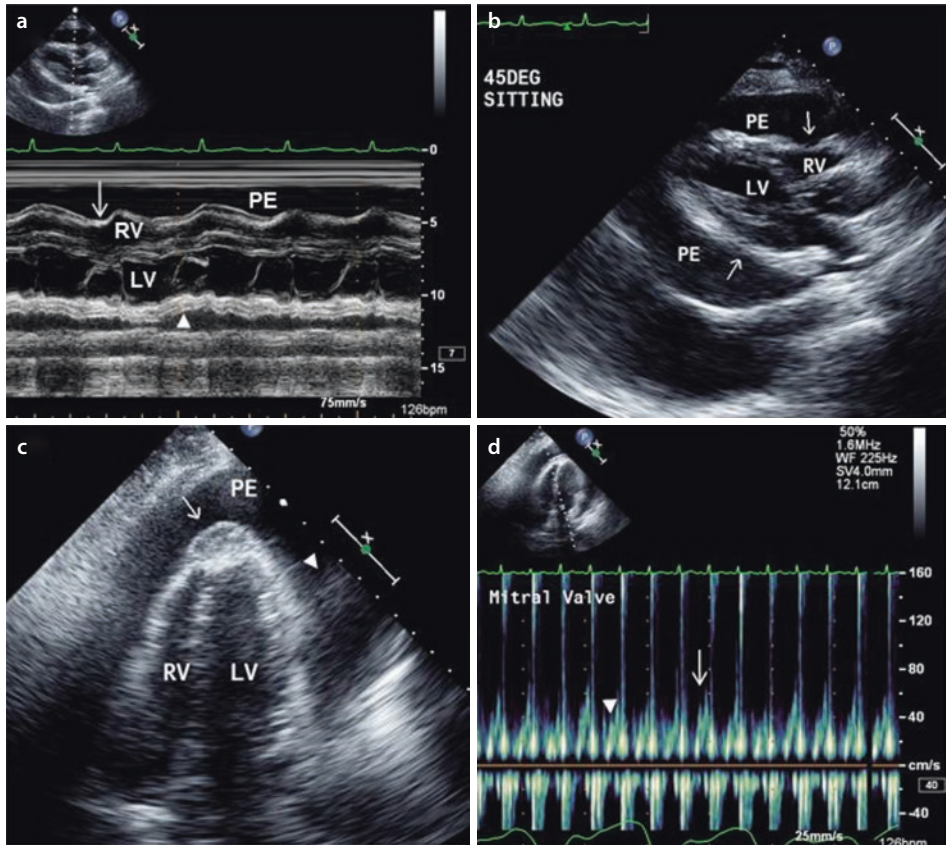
Metastatic breast cancer complicated with a large malignant pericardial effusion and cardiac tamponade. a This two-dimensional (2D) guided parasternal long-axis M-mode echocardiogram demonstrates a large pericardial effusion causing diastolic compression of the right ventricle (RV) anterior (arrow) and posterior left ventricular (LV) (arrowhead) walls. b This 2D parasternal long-axis view demonstrates a circumferential pericardial effusion with visceral pericardial thickening and diastolic compression of the RV anterior and LV inferolateral walls (arrows). c This 2D apical four-chamber view demonstrates a large and circumferential pericardial effusion (PE) associated with severe visceral pericardial thickening and a visceral pericardial mass at the cardiac apex (arrow) and fibrin strands (arrowhead). d Pulse wave Doppler echocardiogram of the mitral inflow demonstrates a significant ($\geq 30\%$) decrease during inspiration (arrowhead) and increase during expiration (arrow) of early diastolic inflow velocities. Adapted with permission from Roldan CA. The Ultimate Echo Guide. Lippincott Williams & Wilkins, Philadelphia 2012
